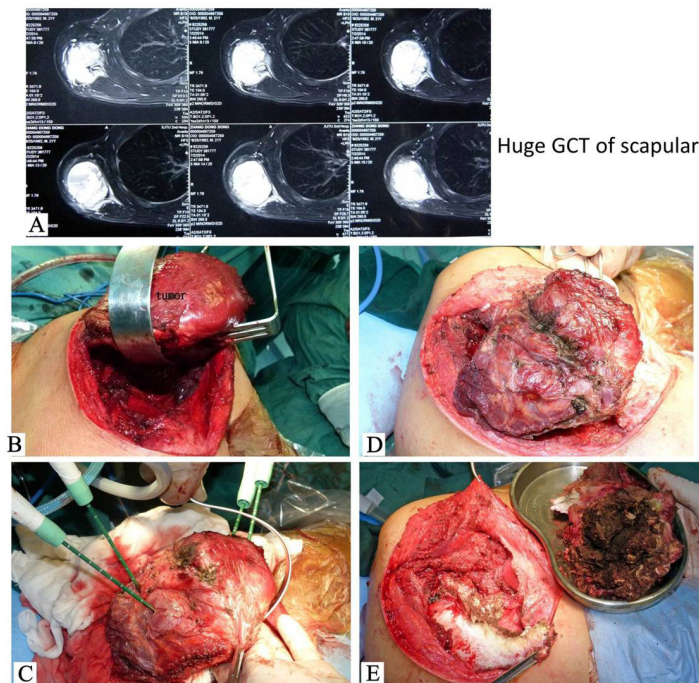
Procedure of MWA for a GCT of the scapula (X-film taken at 8/26/2002) MWA for a case with huge GCT of scapular. A: CT scan. B: Dissect the scapular from the chest wall. C: Insert antenna array and thermometers in to the tumor bulk. D: After MWA. E: Remove the soften devitalized tissues, the shoulder joint was preserved.
